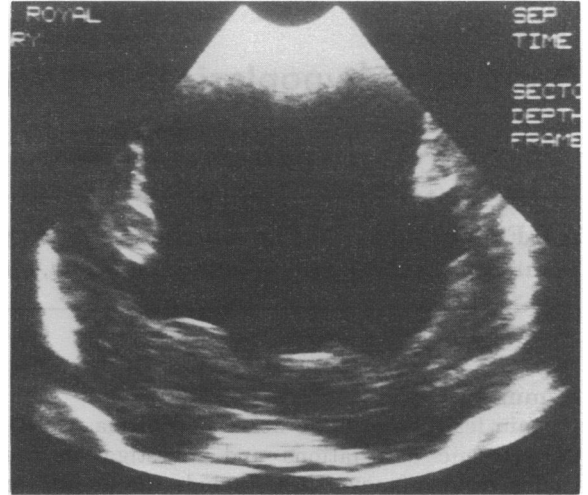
Coronal ultrasound scan in Case 4 showing a large echo-free CSF-filled central cavity: hydranencephaly. The residual cerebral mantle shows no recognizable structures
